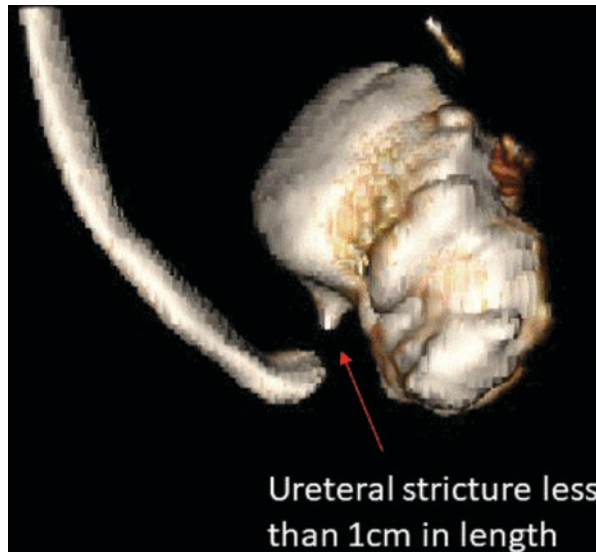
Three-dimensional CT reconstruction showing location and length of ureteral stricture
